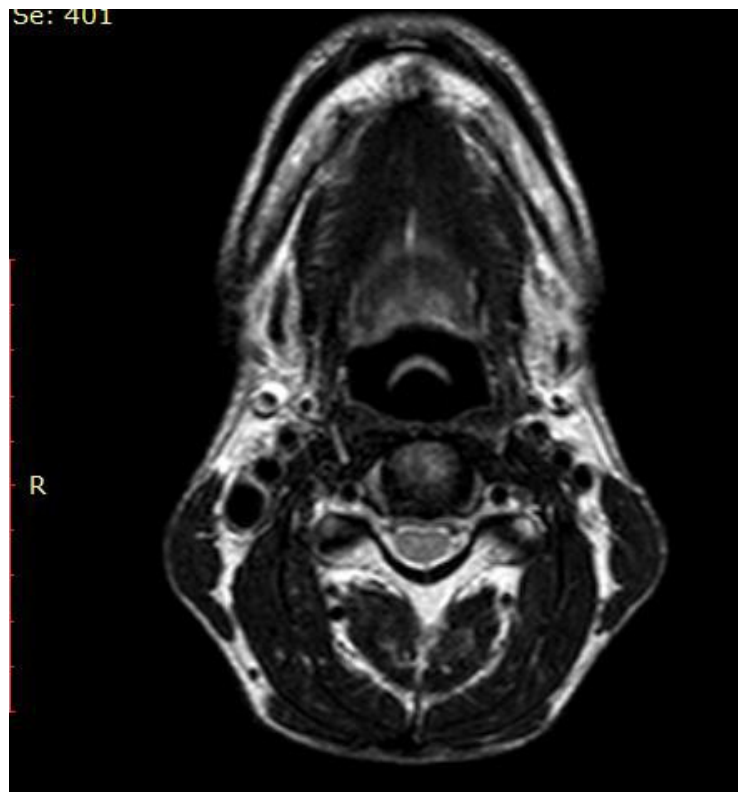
MRI shows submandibular gland atrophy.
